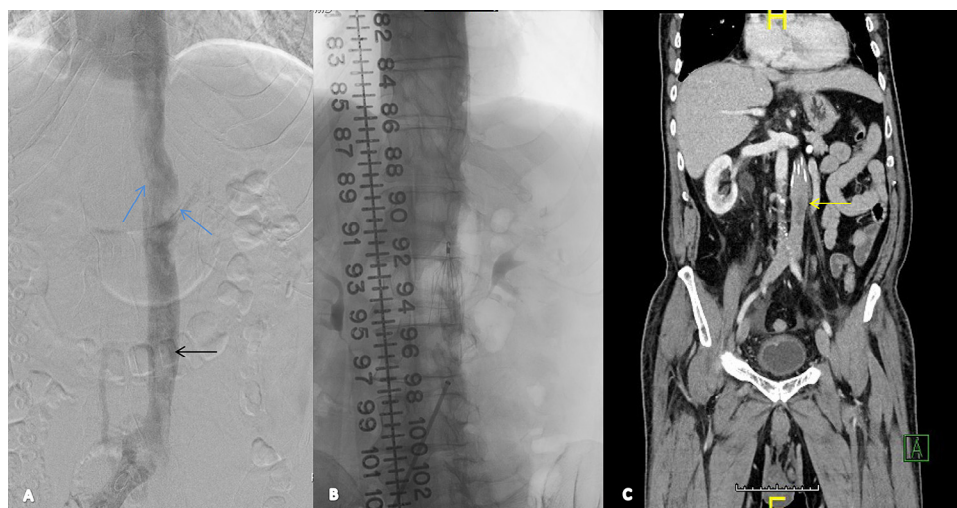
Left to right: (A) digital subtraction angiogram venogram demonstrates IVC thrombus (black arrow) and renal vein inflow (blue arrows), (B) infrarenal IVC filter placement, and (C) coronal computed tomography confirming IVC filter placement above the IVC thrombus (yellow arrow). IVC, inferior vena cava.
